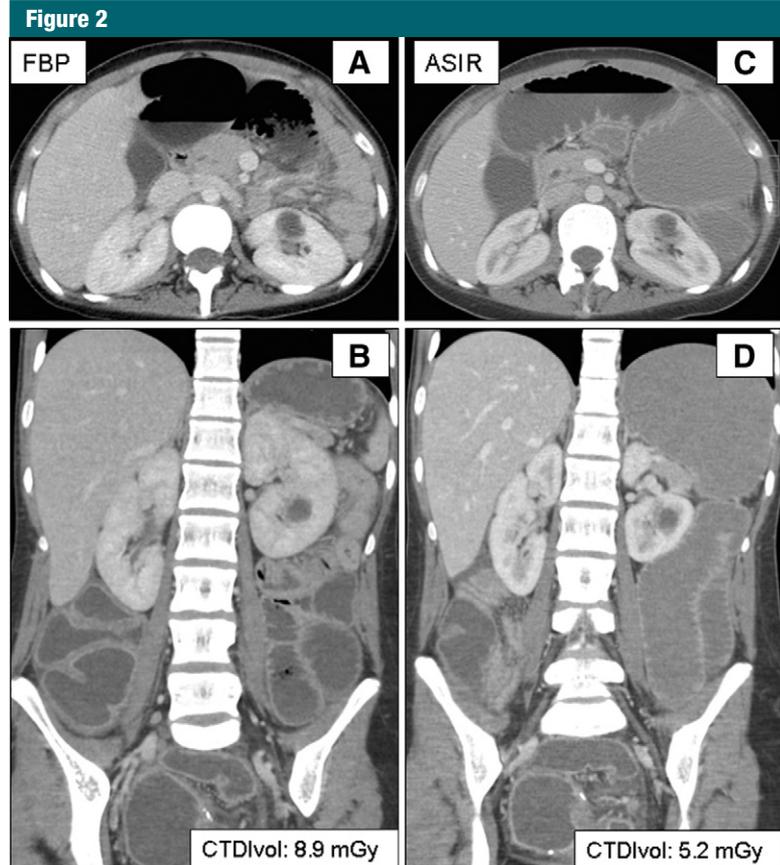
Abdominal CT images in a 17-year-old girl (weight, 39 kg; pink zone) obtained to evaluate possible bowel obstruction after colectomy and J-pouch construction for Crohn disease. *A*, Transverse and *B*, coronal images reconstructed with FBP (8.9 mGy, 107–189 mA, 120 kVp) show numerous dilated fluid-filled small-bowel loops and 1.6-cm left renal hypodensity. Follow-up, *C*, transverse and *D*, coronal images reconstructed with ASIR (5.2 mGy, 75–150 mA, 120 kVp) resulted in 41.5% CTDI_{vol} reduction and did not affect lesion detection or image quality.
